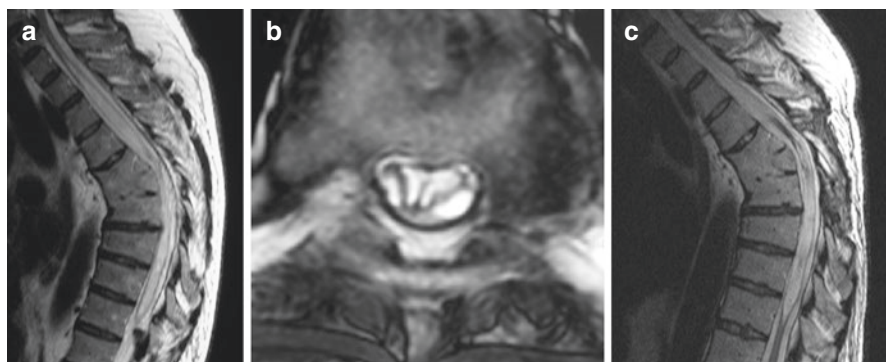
(a) This T2-weighted MRI scan of a 49-year-old man shows a posttraumatic syrinx Th1–Th10 10 years after suffering a fracture at Th10 without any neurological deficits. A kyphotic deformity developed. (b) The axial scan at Th6 shows a posterior adhesion of the spinal cord to the dura resembling a posttraumatic arachnopathy. (c) The postoperative scan after arachnolysis and duraplasty at Th6 demonstrates a decrease of the syrinx (see also Fig. 9.8)
